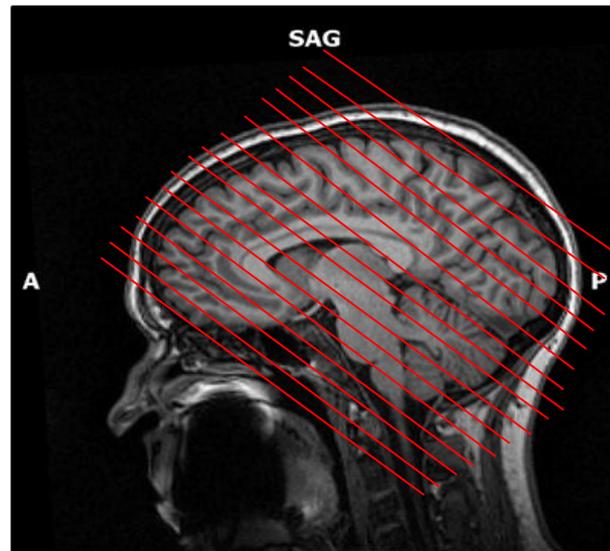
Functional coverage on a T1-weighted image. Each volume consisted of 44 slices with a slice thickness of 2.5 mm.
